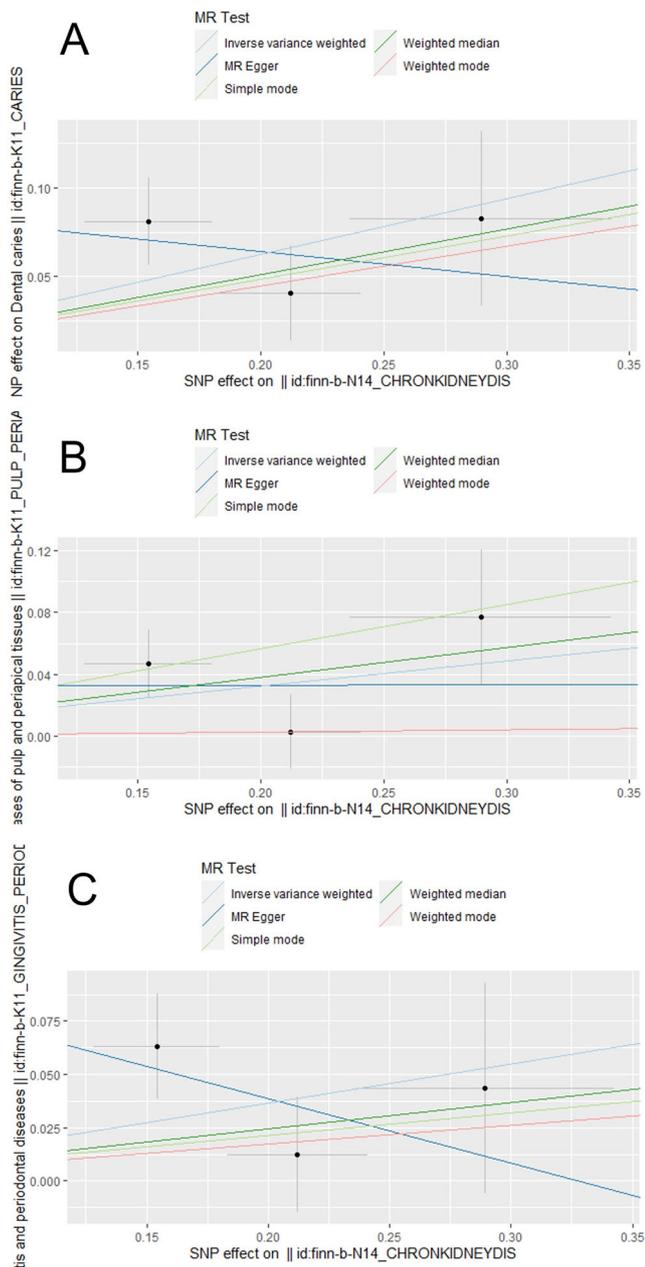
MR analysis of CKD and oral diseases. (A) MR analysis of CKD and dental caries. (B) MR analysis of CKD and diseases of the pulp and periapical tissues. (C) MR analysis of CKD and diseases of the gum and periodontal tissues. The light blue lines were IVW analysis and MR Fitting results. A showed that with the increase of CKD, the risk of caries was also increased, and it was statistically significant.
